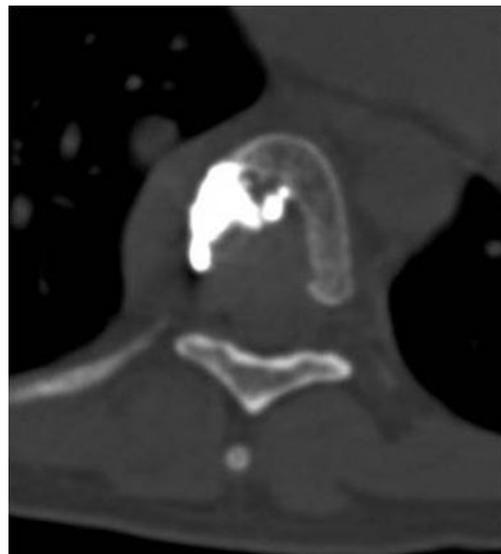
CT after coblation vertebroplasty in the patient with a cholangiocarcinoma metastasis
